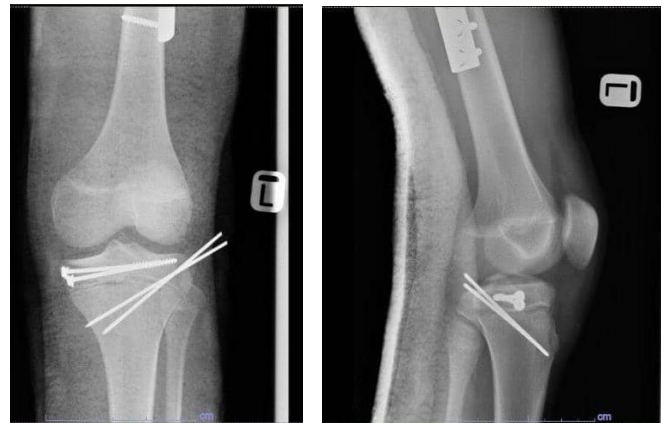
Post operative plain radiograph of the left knee AP and lateral view
